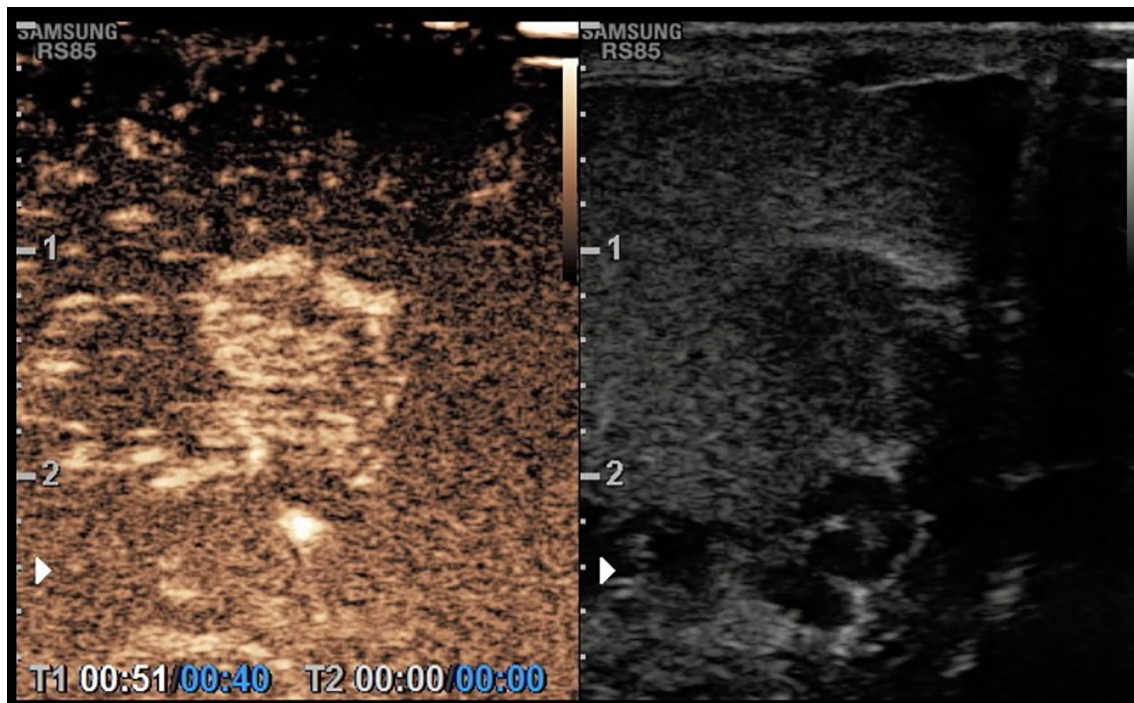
contrast-enhanced ultrasonography (CEUS) image shows contrast enhancement of the mass
